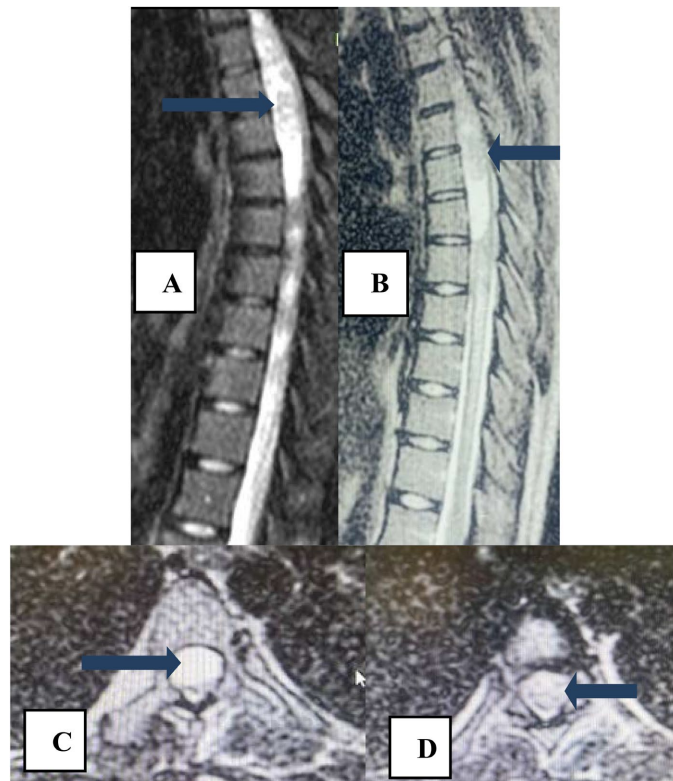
MRI of the thoracic spine, sagittal slices, (A, C and D) T2 sequence and (B) T1 sequence showing a heterogeneous intramedullary lesion with a fleshy and cystic appearance (C) and irregular contours, consistent with a tumor (D).
